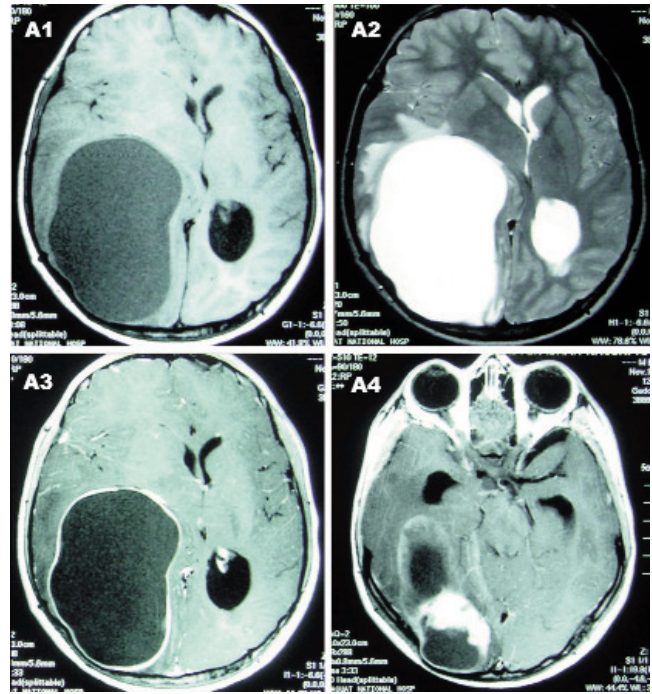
(A1, A2) T1 and T2 axial MRI sequence showed a huge well defined cystic mass in right temporo-parieto-occipital region, with mild vasogenic oedema, but severe mass effects. (A3, A4) Post contrast study demonstrated enhancement of the cyst wall with enhancing mural nodule attached to meningeal covering.
